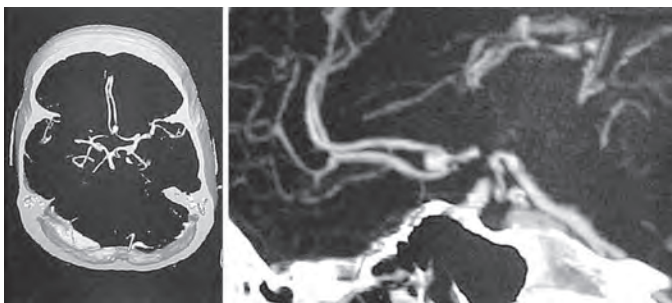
Reconstruction CT angiogram appearance of the ACoAA
